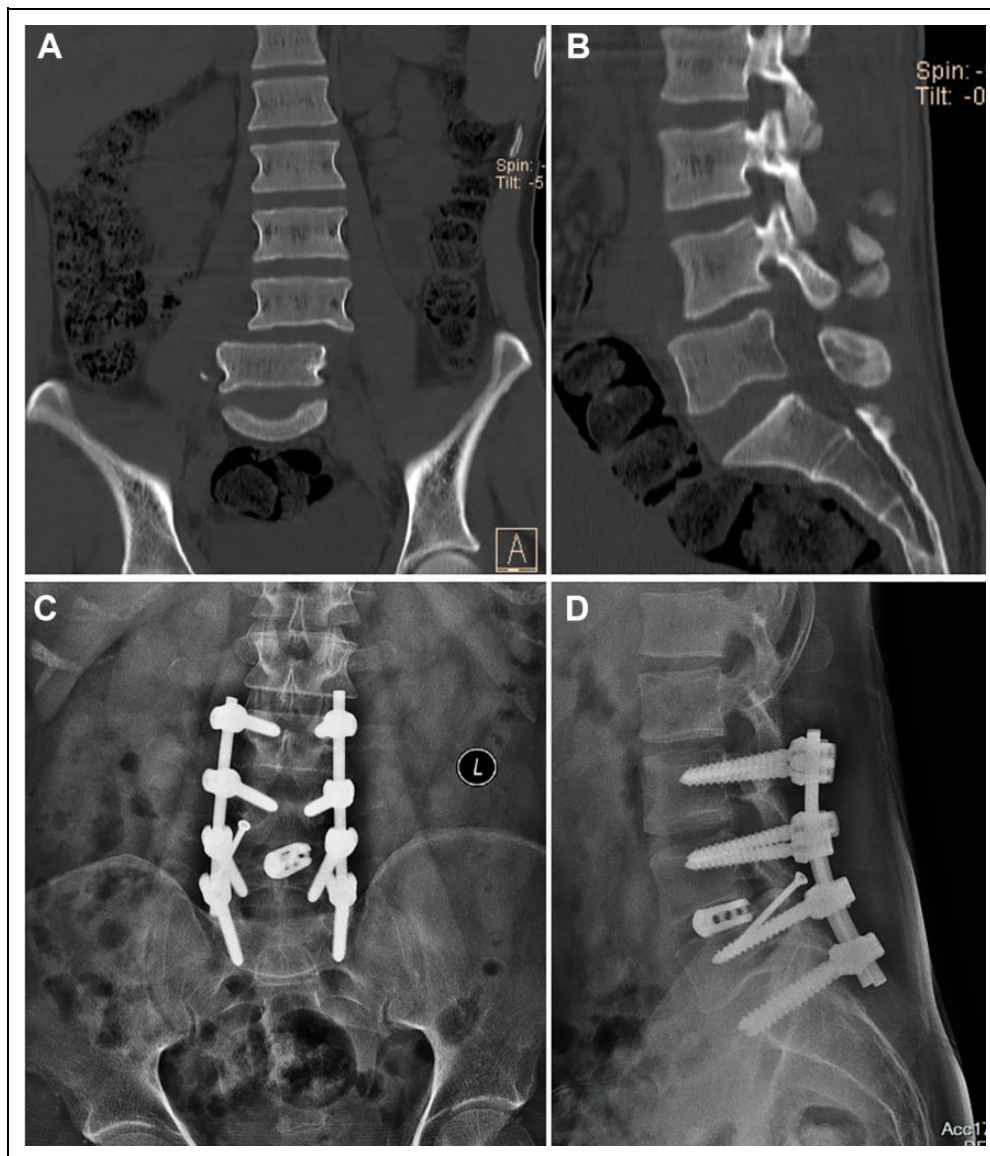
A 36-year-old male patient who has sustained a type 3b injury in a motor vehicle accident. (a, b) Coronal and sagittal CT images show the presence of combined lateral and sagittal translation (retrolisthesis) of vertebral column at L4-5 level. (c, d) The injury has been treated by complete reduction, posterior fixation from L3-S1, L4-5 interbody fusion and facet fixation.
